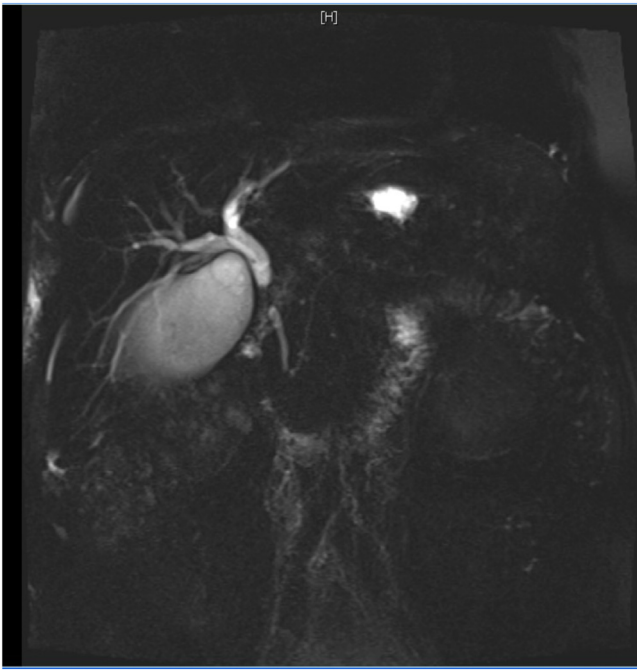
CT scan demonstrating distal abrupt caliber change and a soft tissue density mass measuring 1.3 cm was noted in the hepatic duct.
